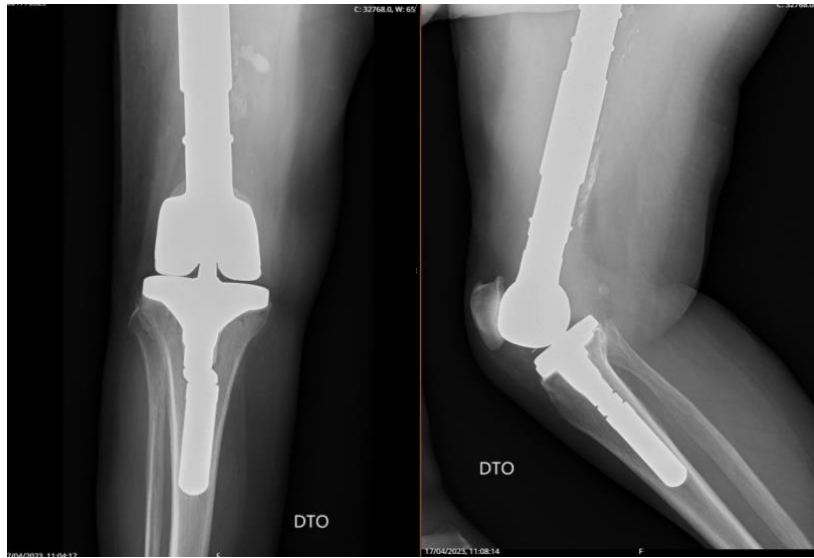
Conventional radiographs (frontal and lateral views) showing the formation of heterotopic ossification (asymptomatic).
